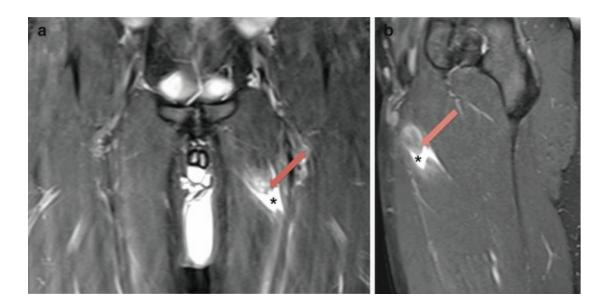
A 20-year-old male athlete with a tear of the right adductor longus at the proximal myotendinous junction. (a) Coronal and (b) sagittal short tau inversion recovery MRI show a tear at the myotendinous junction with retraction of the proximal fibers (*arrow*). Note the presence of hemorrhage delineating the torn muscle (*asterisk*)
